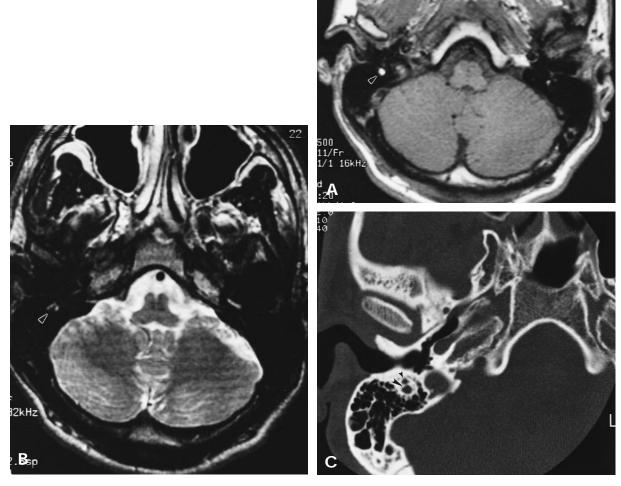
A, T₁-weighted pregadolinium MRI showing focal hyperintense right mastoid lesion (*arrow*). B, T₂-weighted image depicting same lesion (*arrow*). C, Temporal bone CT scan showing mastoid mucocele (*large arrow*) just posterior to fallopian canal (*small arrow*). Note erosive changes of bony partition between the two structures.
